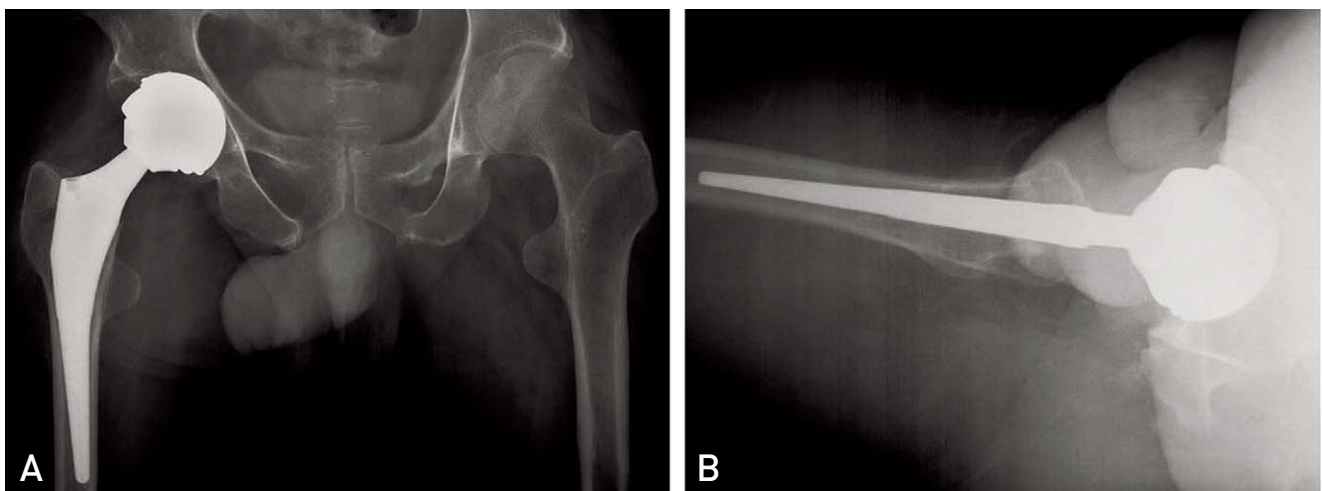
Plain radiographs taken at two year postoperatively. (A) Both hips anteroposterior and (B) right hip lateral radiographs showing a well bone ingrown acetabular cup and femoral stem. Acetabular abduction and anteversion angles were 57° and 14°, respectively.
